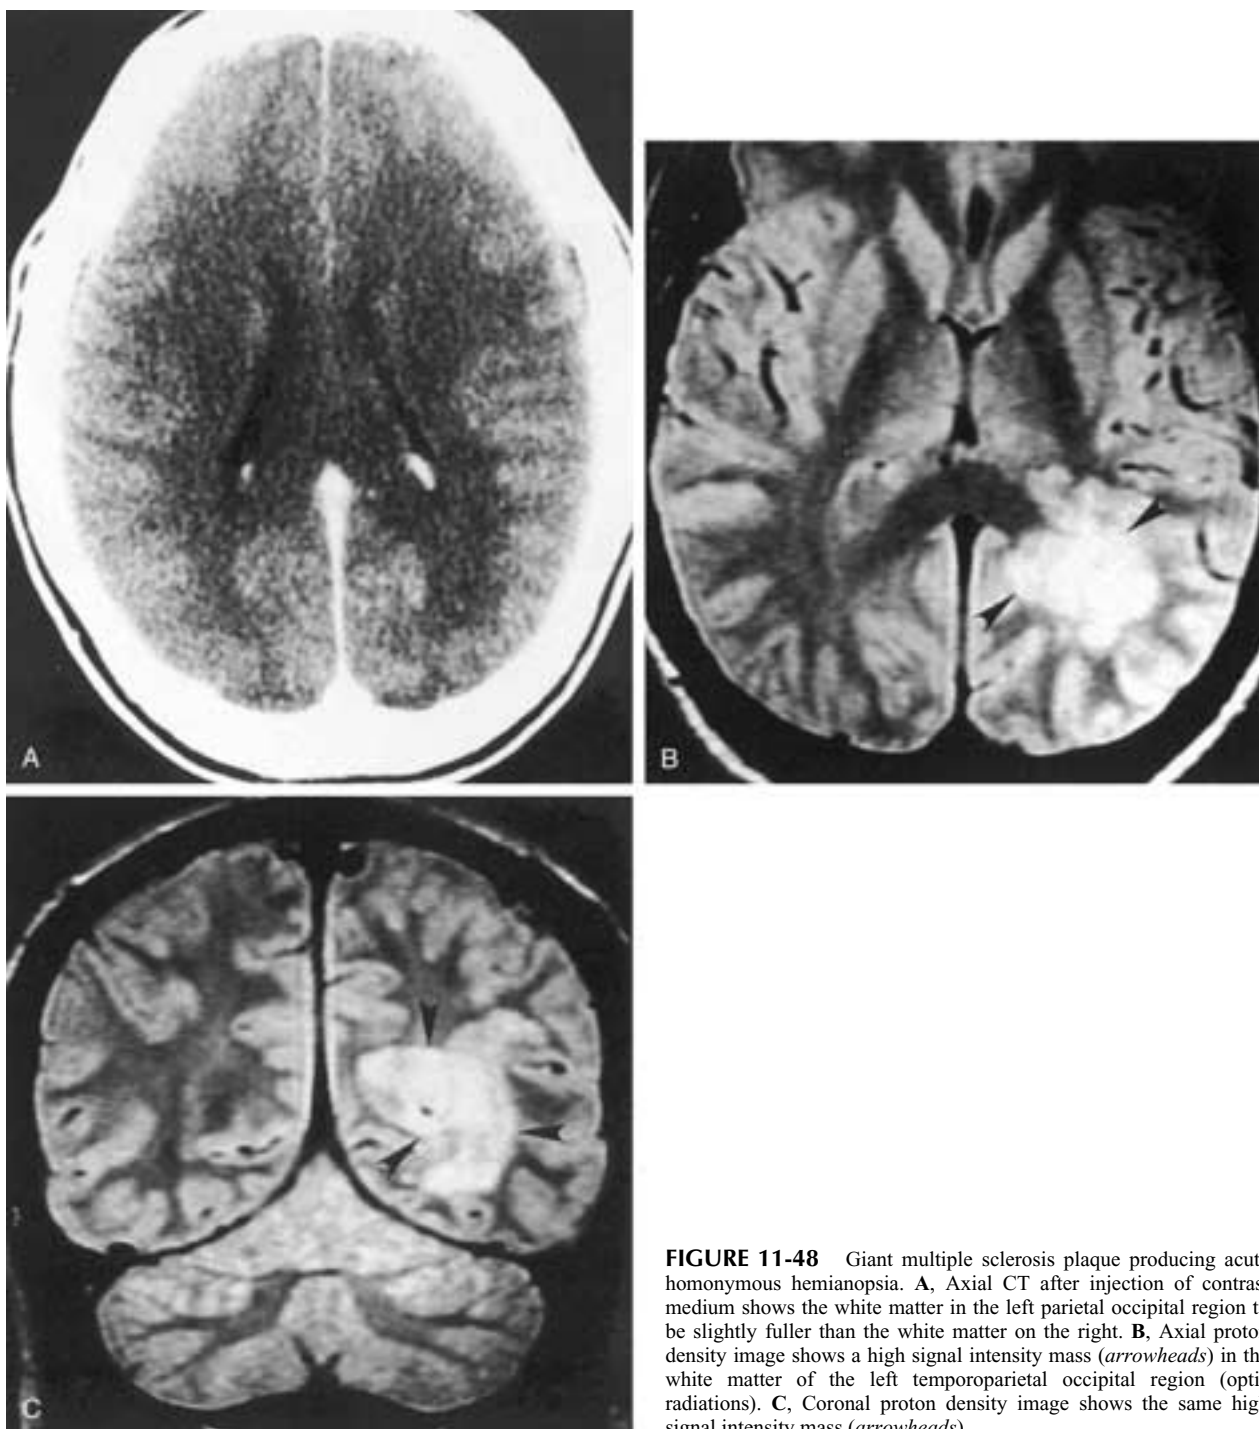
Giant multiple sclerosis plaque producing acute homonymous hemianopsia. A, Axial CT after injection of contrast medium shows the white matter in the left parietal occipital region to be slightly fuller than the white matter on the right. B, Axial proton density image shows a high signal intensity mass (*arrowheads*) in the white matter of the left temporoparietal occipital region (optic radiations). C, Coronal proton density image shows the same high signal intensity mass (*arrowheads*).
